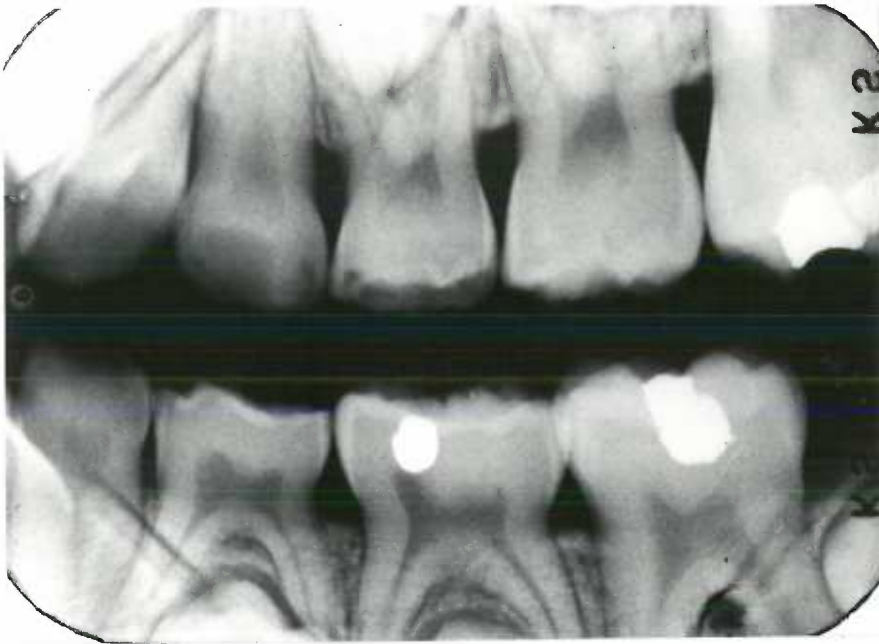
Patient 6. Age ten years, bitewing radiograph shows lack of alveolar bone loss.
